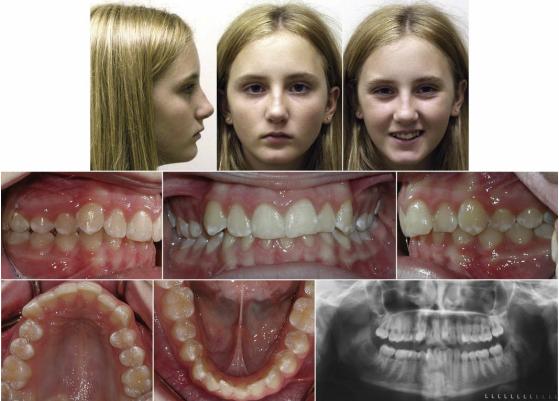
Pretreatment intraoral/extraoral photographs and panoramic radiograph.
